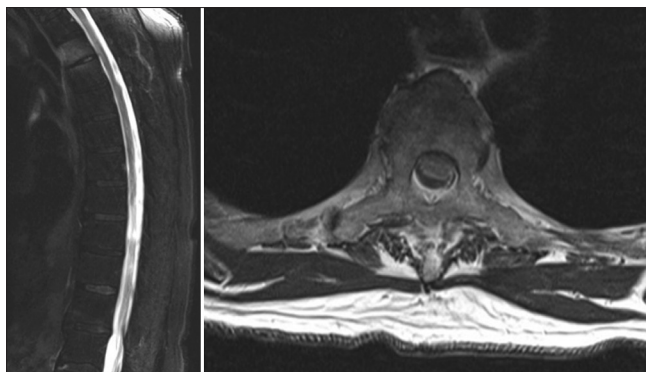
MRI T2-weighted sagittal and axial images. Ventral displacement thoracic spinal cord, moderate flattening, anterior herniation through the dura T3-5
